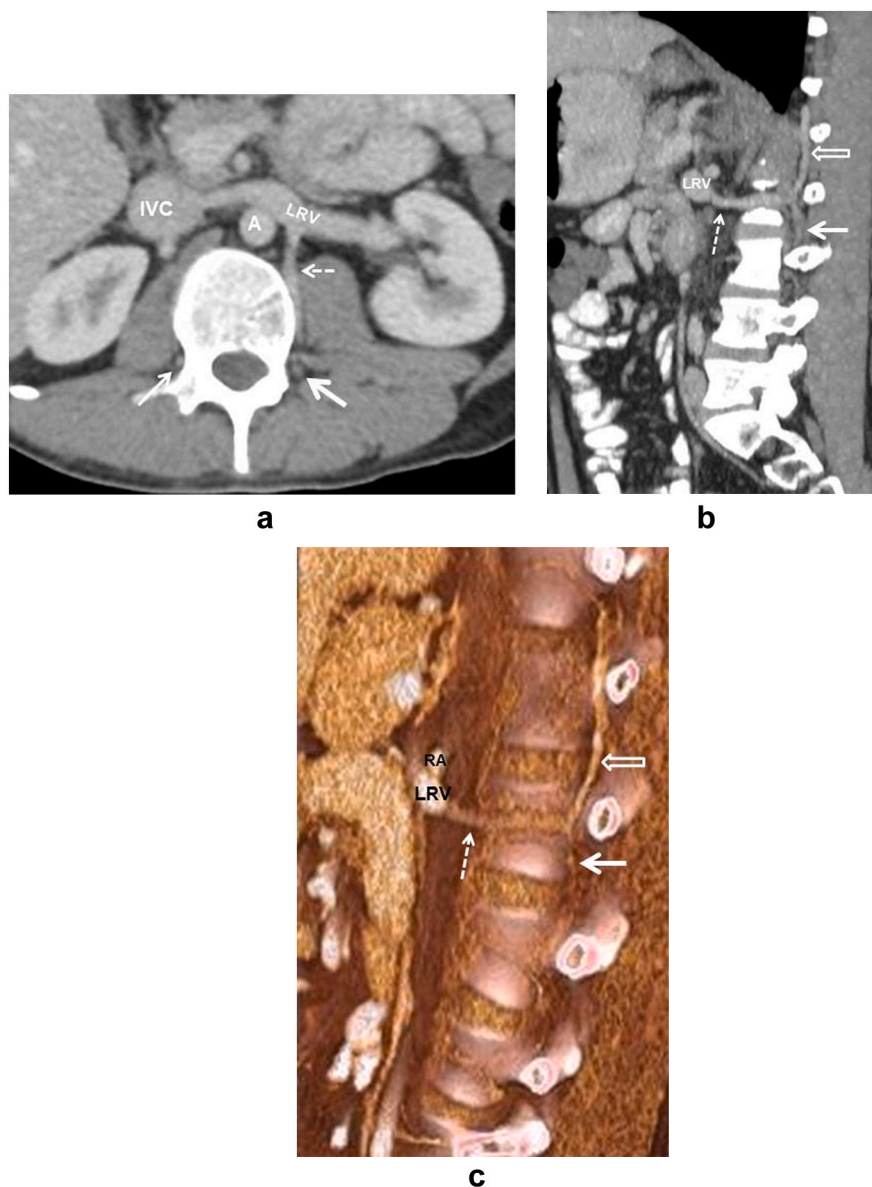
Axial plane contrast-enhanced CT image at L2 vertebra level (a), sagittal plane reformatted CT image (b) and (c) sagittal plane volume rendering technique (VRT) image show normal anatomy of the ALCV (dashed arrows) in a 25-year-old male patient with preaortic LRV. A: Abdominal aorta IVC: Inferior vena cava LRV: Left renal vein RA: Left renal artery. Thick solid arrows: Left ALV. Thin solid arrow: Right ALV. Open arrow: Hemiazygos vein.
